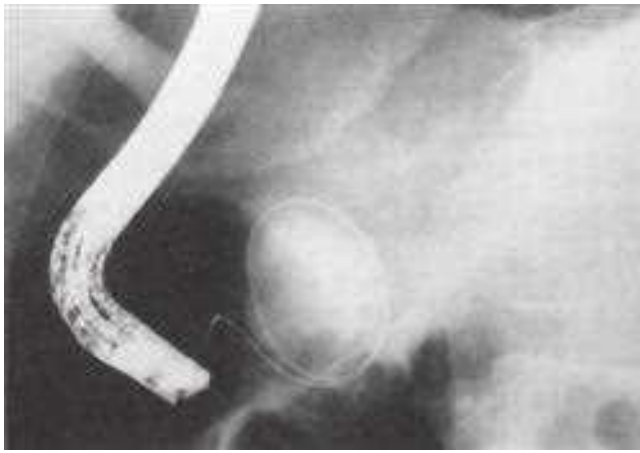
Technique of endoluminal cystogastrostomy. A. Endoscopic ultrasound (EUS)-guided transgastric puncture of pancreatic pseudocyst. B. Transgastric stents placed across fused posterior wall of stomach and anterior wall of pseudocyst. (Reproduced with permission from Chauhan SS, Forsmark CE. Evidence-based treatment of pancreatic pseudocysts. *Gastroenterol* 2013; 145: 512 Copyright Elsevier.)
